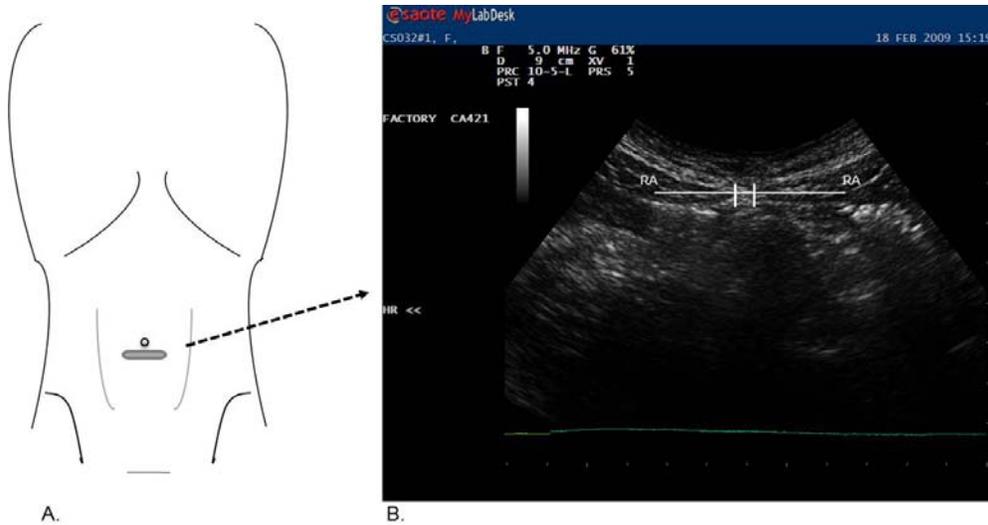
A. Linea alba (LA) imaging site. B. Transverse ultrasound image of the linea alba showing a horizontal reference line along which the length of the inter-rectus distance, (IRD), defined as the horizontal distance between the medial aspects of the left and right rectus abdominis (RA) muscles, was made.
